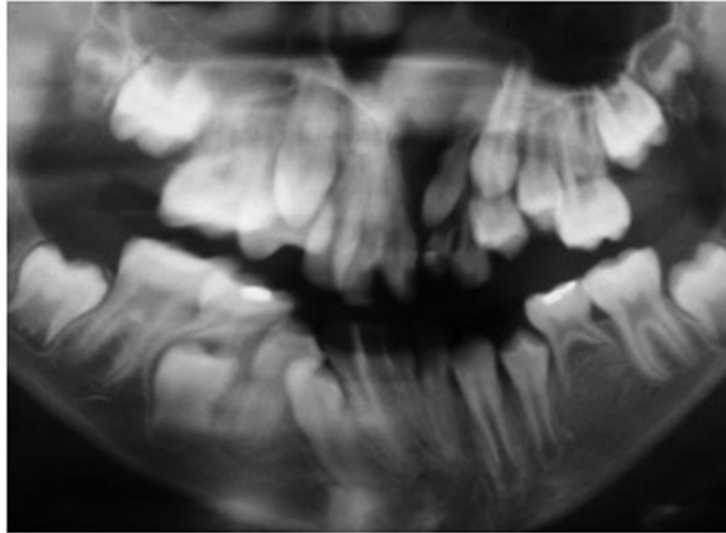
Panoramic radiographic revealing presence of peg-shaped permanent lateral incisor distally to the cleft in patient with complete unilateral cleft lip and palate.
